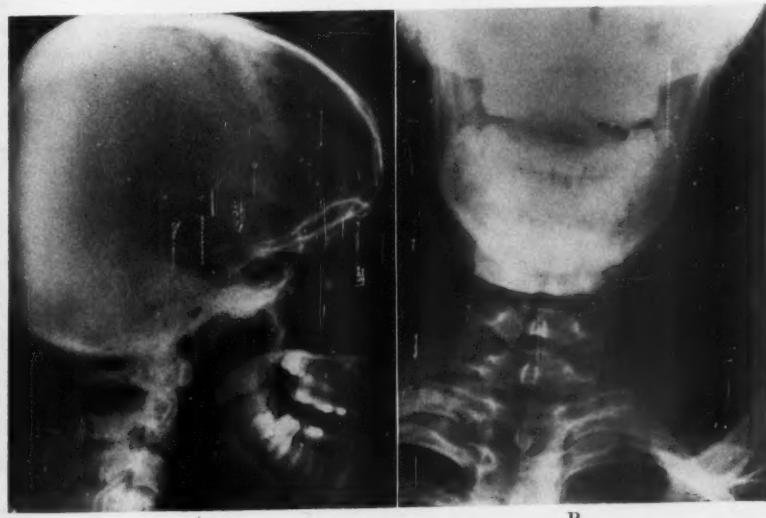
A AND B. Roentgenogram of the neck in posteroanterior and lateral projections in Case 1 showing soft tissue bulging and retropharyngeal air.
